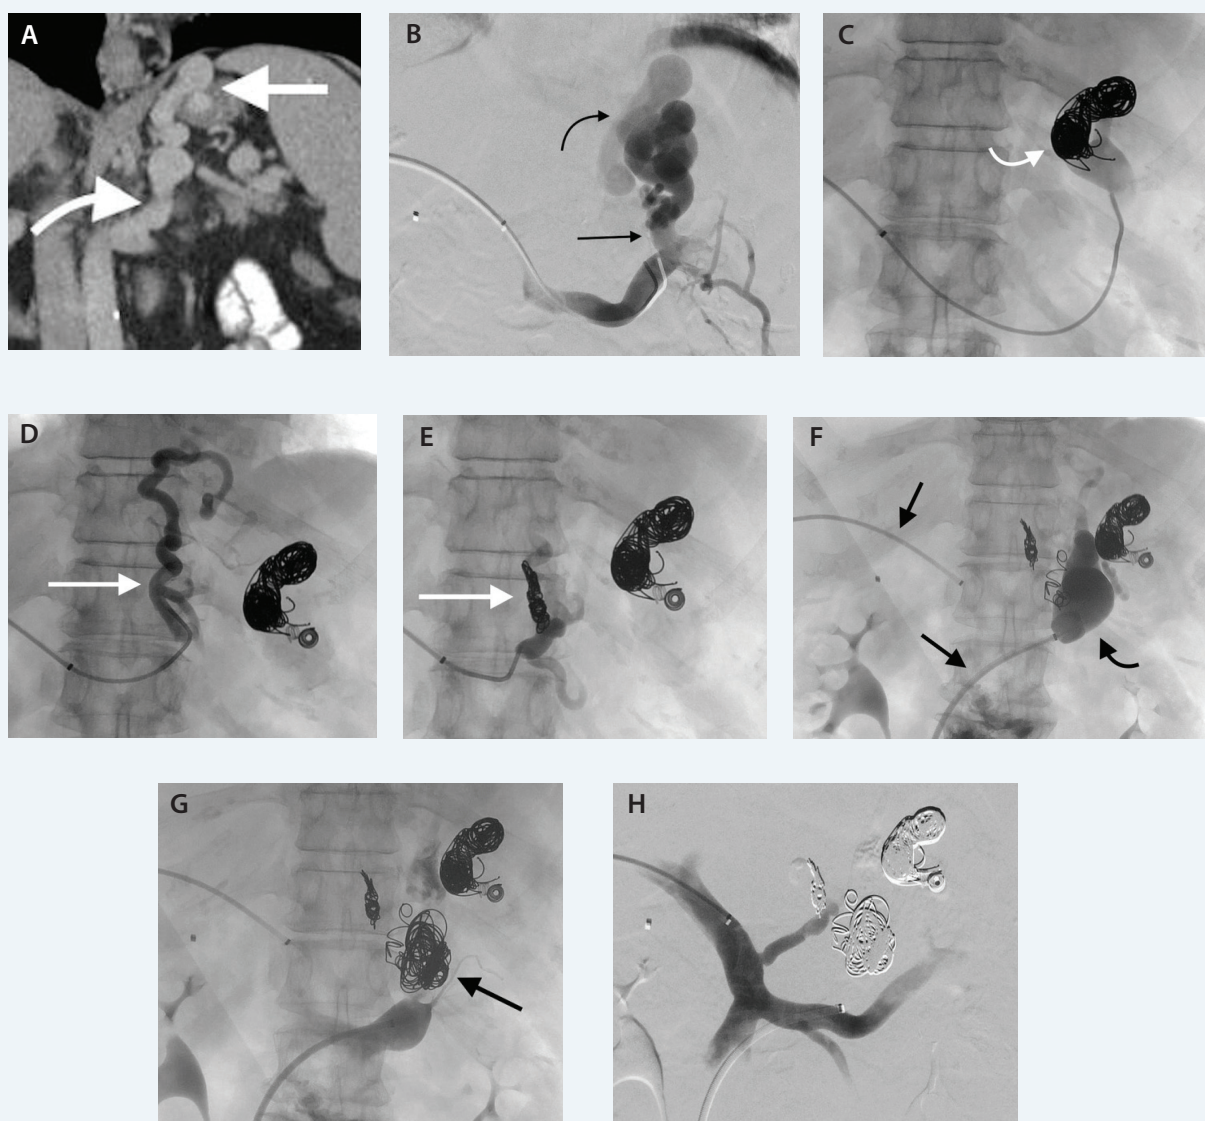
Coronal reconstruction of an abdominal CT scan demonstrating a large feeding coronary vein (curved arrow) into gastric varices (straight arrow) (A). Through a transhepatic approach, splenic venography shows a large, short gastric vein (straight arrow) feeding into gastric varices (curved arrow) (B). Gastric varices embolized with Interlock™-35 coils (curved arrow) until cessation of flow (C). Coronary vein feeder (straight arrow) catheterized with a cobra tip-shaped catheter (D). Coronary vein feeder embolized with Interlock™-35 coils (straight arrow) (E). The splenorenal shunt was cannulated, and venography was done through the occlusion balloon (curved arrow). The transhepatic and transfemoral sheaths are marked with straight arrows (F). Shunt embolized with Interlock™-35 coils (straight arrow) and sclerosing agent until cessation of flow (G). Concluding transhepatic portal venography demonstrates complete obliteration of gastric varices (H).
